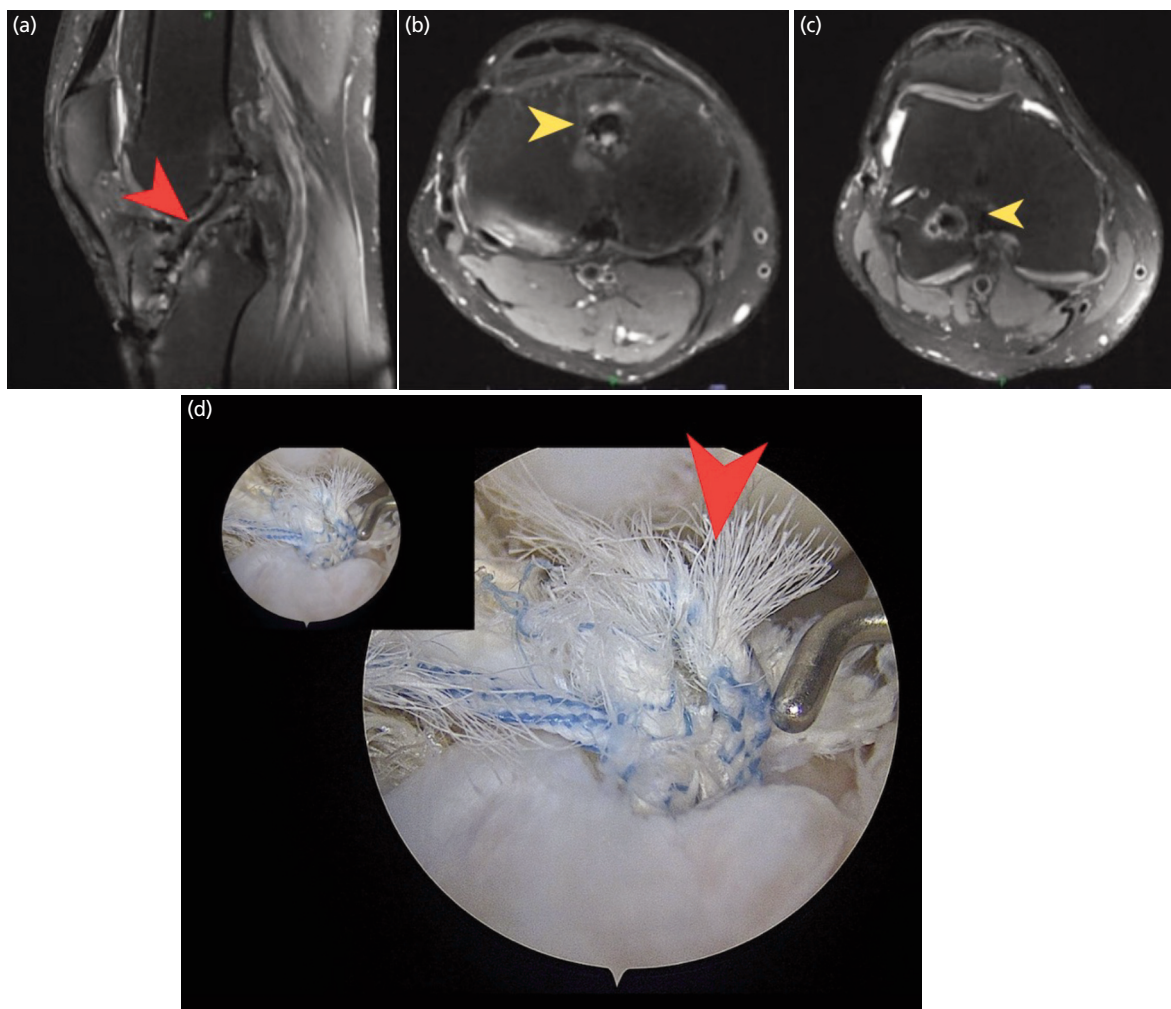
MRI images of the right knee one year after revision ACL reconstruction with the MUIB technique. (a) Sagittal image shows an intact and well-incorporated ACL graft with normal signal intensity and proper anatomical alignment, without evidence of graft disruption (red arrowhead). (b) Axial images at the levels of the tibial and (c) femoral tunnels demonstrate well-preserved tunnel morphology (yellow arrowhead), with no signs of tunnel widening, peri-tunnel osteolysis, or cystic changes. (d) The intra-operative arthroscopic image demonstrates a torn suture tape (red arrowhead), while the ACL graft itself remains largely intact. Careful inspection also shows well-preserved femoral and tibial tunnels, with no evidence of tunnel widening or peri-tunnel bone loss.
